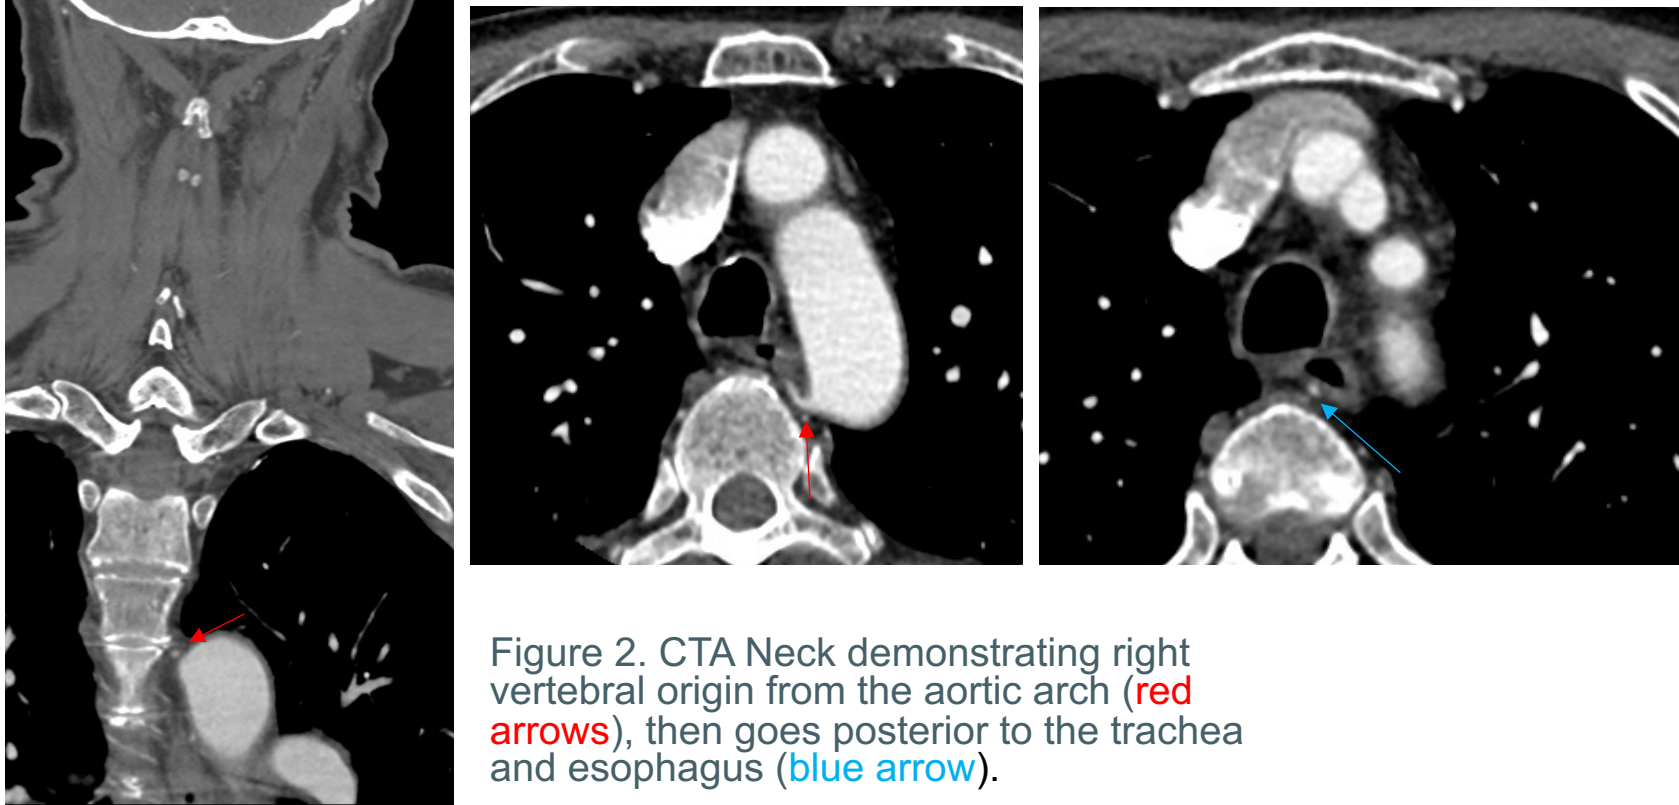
CTA Neck demonstrating right vertebral origin from the aortic arch (red arrows), then goes posterior to the trachea and esophagus (blue arrow).
